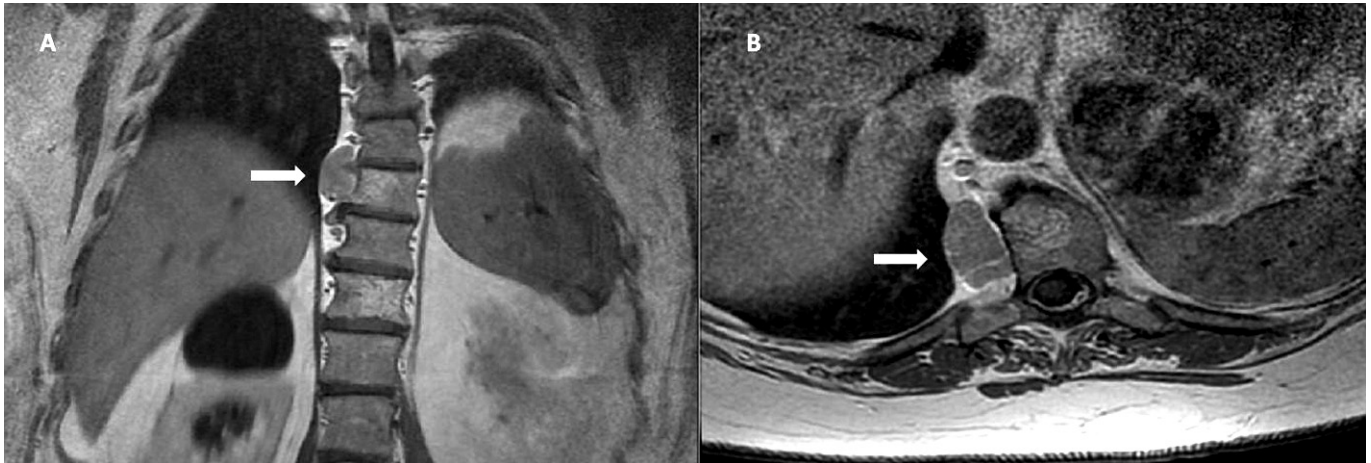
Magnetic resonance images. A right-sided well defined paravertebral lesion is shown. A) sagittal view; B) cross-sectional view.
